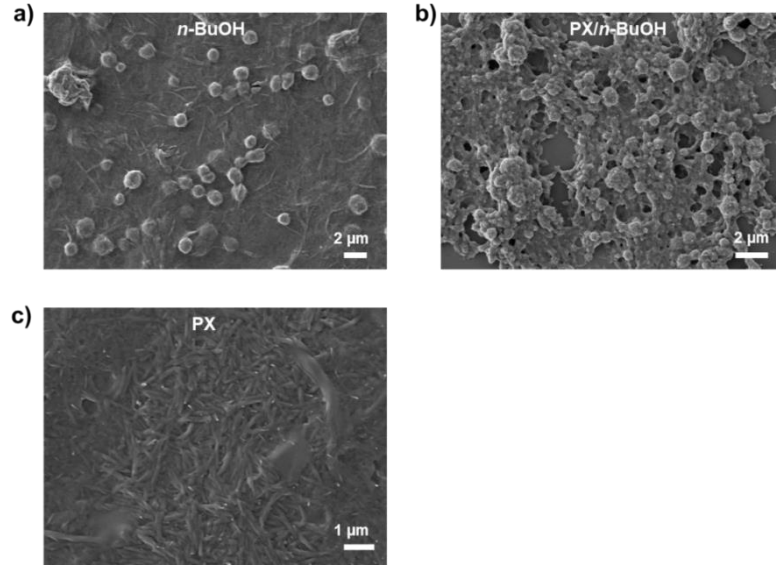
SEM images of PCSPCC+AlCl₃ aggregates treated by ultrasound in a) *n*-BuOH, b) PX/*n*-BuOH (v/v, 1/1), and c) PX.
